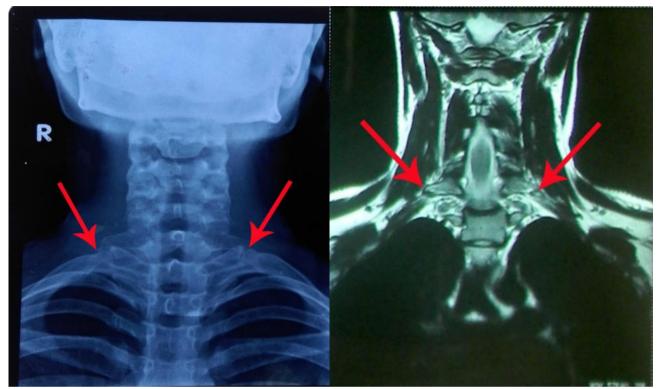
Chest radiograph demonstrating bilateral cervical ribs (arrowed).
